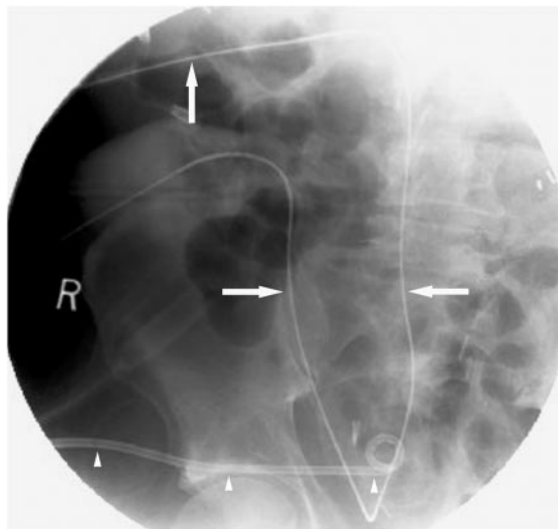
Ureteral urinoma in a 40-year-old man with recurrent fevers following pelvic exenteration and ileal loop diversion. (a) Contrast-enhanced delayed phase CT scan demonstrates a presacral urine collection with high attenuation. A percutaneous urinoma drainage catheter (not shown) was placed. (b) Pyelogram obtained after injection of contrast material through the urinoma drainage catheter shows communication of the urinoma with the ileal loop (arrow). Both kidneys were obstructed, and bilateral percutaneous nephrostomy was performed. Management options included ureteral stent placement (if technically possible) and, as a last resort, surgical revision. Stent deployment was attempted. (c) Spot radiograph obtained during stent placement demonstrates a guide wire that has been placed antegrade via the right kidney through the ureteral anastomosis and out the ileal loop. After percutaneous access to the ileal loop via the kidney was established, an exchange-length guide wire (arrows) was inserted to help place a retrograde catheter. A percutaneous nephrostomy catheter (not shown) was left in place. Arrowheads indicate the percutaneous urinoma drainage catheter. (d) Photograph of an 8-F, 30-cm biliary urinary drainage catheter (Boston Scientific) demonstrates that the catheter is long with a single pigtail. The catheter is suitable for ureteral stent placement in patients with ileal loops. In such patients, the distal portion of the stent is external to the patient and is confined within the ileostomy drainage bag. This particular design with a Luer-lock hub facilitates over-the-wire exchanges. These catheters come in lengths of 30 or 45 cm and are typically 8–10 F in diameter. (e) Lateral radiograph shows a right percutaneous nephrostomy catheter (arrow) and a right biliary urinary drainage catheter (arrowheads) placed across a right ureteral–ileal loop anastomotic injury.
